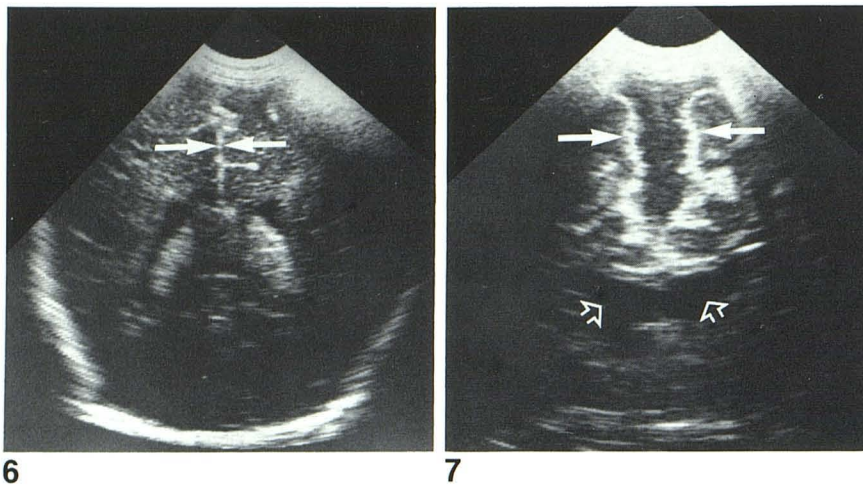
Semiaxial section using 7.5-MHz transducer in normal control. Ventricles are of normal size; interhemispheric fissure and falx appear as single specular reflection (arrows). Note loss of information from deeper parts of brain owing to marked attenuation of high-frequency sonographic technique.
